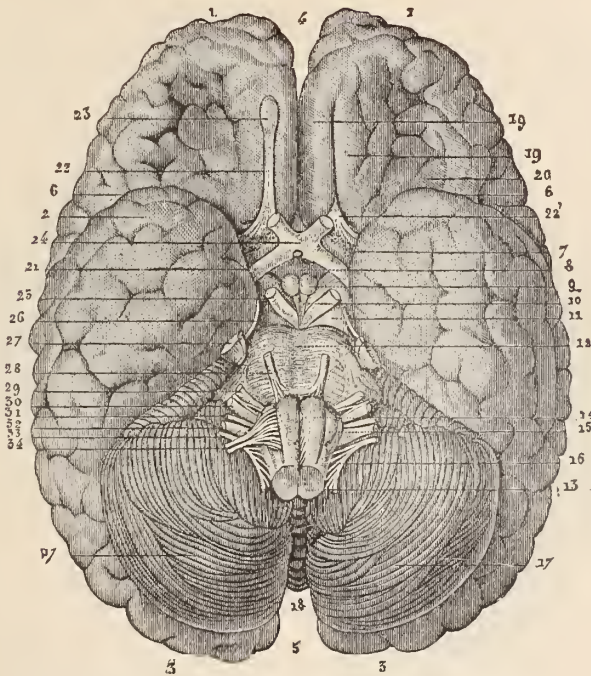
INFERIOR ASPECT OF THE ENCEPHALON. (Hirschfeld.)
